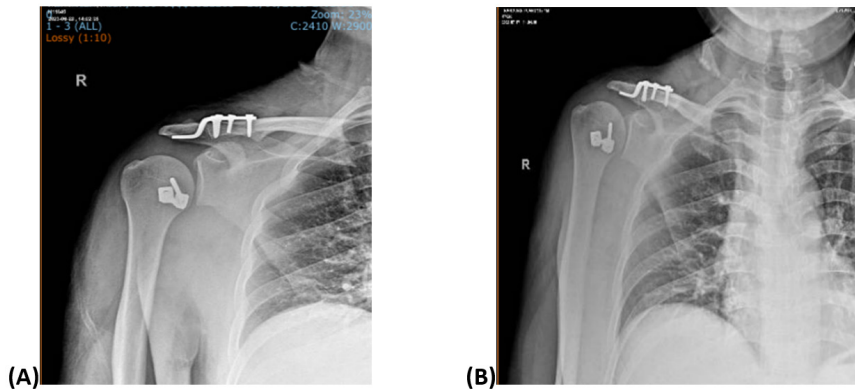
Postoperative X-rays of the shoulder joint (A); after 3 months follow-up (B)
